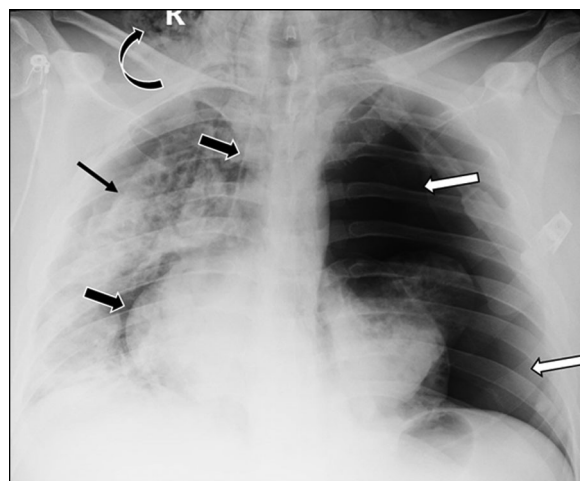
Chest x-ray, anteroposterior view, showing large left tension pneumothorax (white bold arrow) with significant displacement of mediastinum to the right, small right pneumothorax (black arrow), pneumomediastinum (black bold arrows), and subcutaneous emphysema in the lower neck (curved black arrow).
